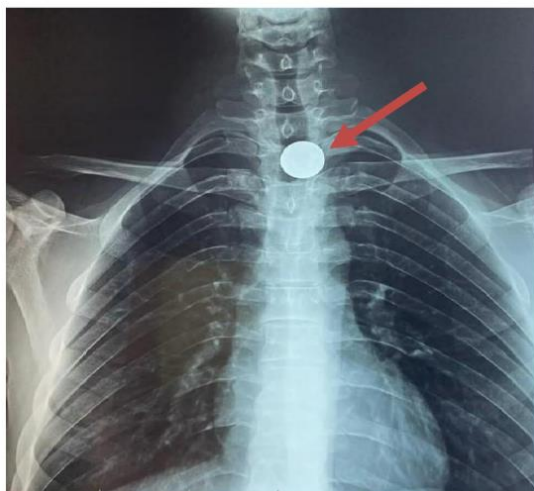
Frontal chest x-ray showing the presence of a coin in the upper third of the esophagus.
